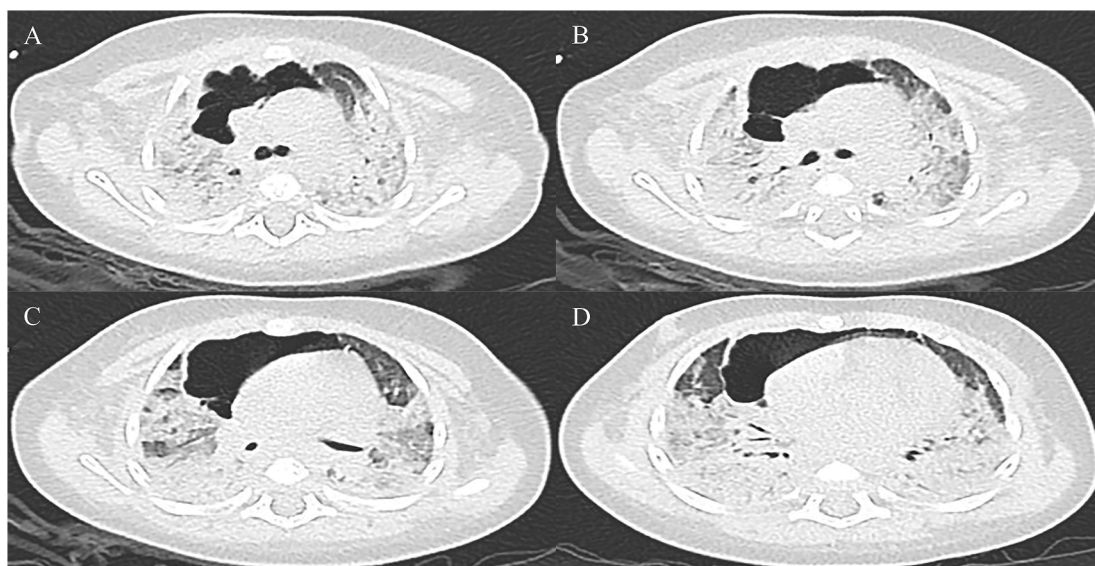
Chest CT before ECMO treatment.
